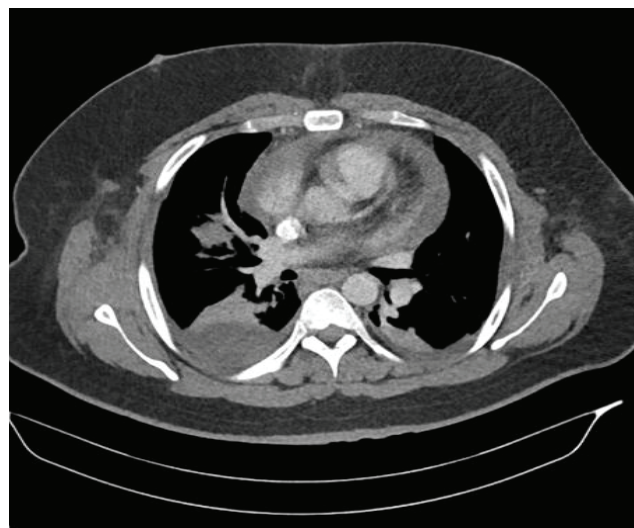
CT scan showing a large pleural effusion in the right pleural cavity and a moderate amount of pericardial effusion
